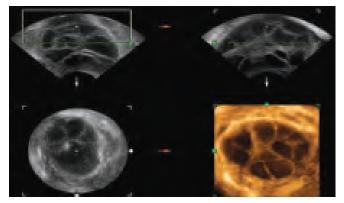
Transvaginal three-dimensional ultrasound scan of a hyperstimulated ovary at the time of guided aspiration of the oocytes. Note the tip of the needle within the follicle in C plane
